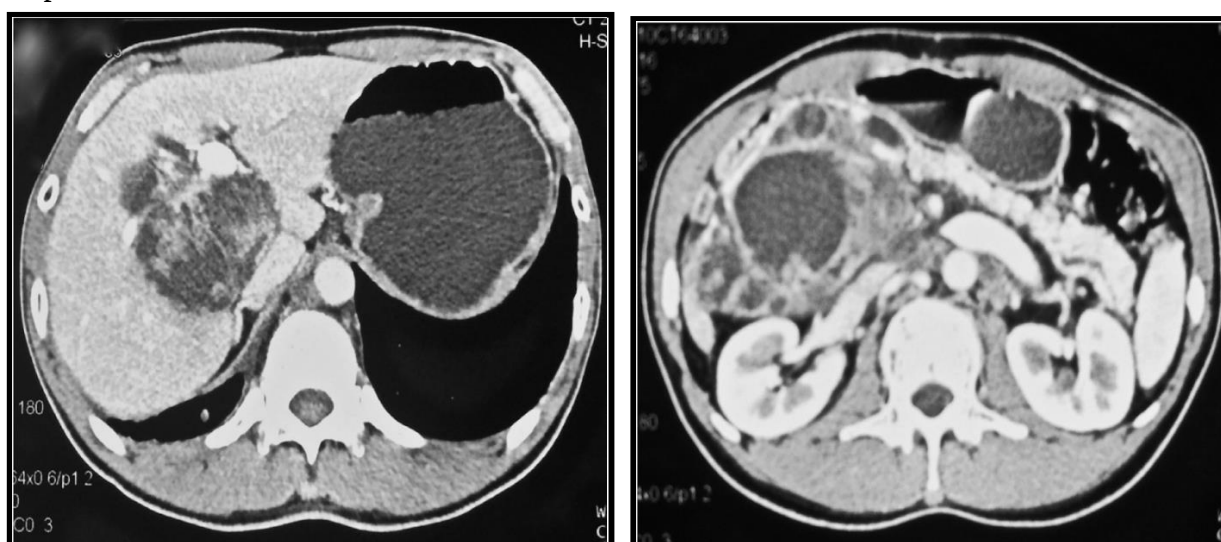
2B: Contrast-enhanced CT of a pancreatic cystic lesion with multiple cystic wall nodules over the pancreatic head and sharp enhancement of the cystic wall nodules and septation. The main pancreatic duct was extended. The abdominal, retroperitoneal, lesser omentum with multiple enlarged lymph nodes.
